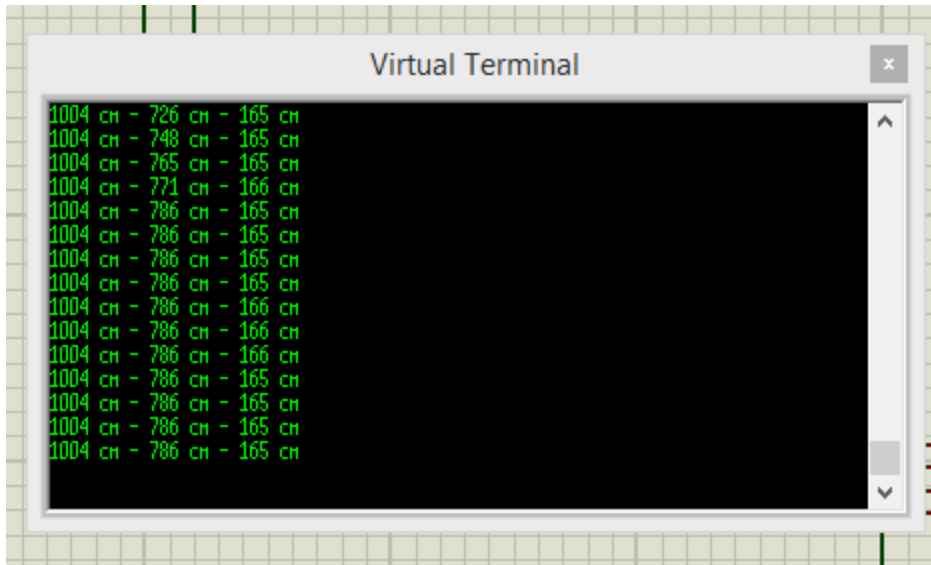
Virtual terminal output of the system in the Ultrasonic Sensor Probe*
